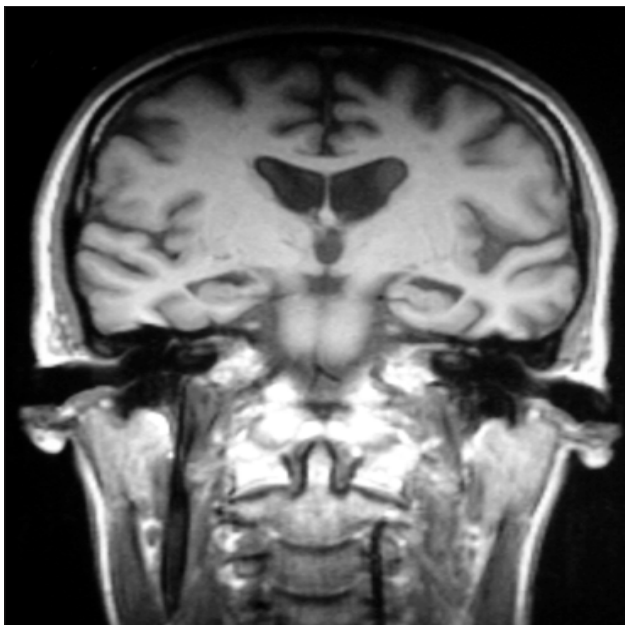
MRI scan showing cortical atrophy and bilateral hippocampal atrophy.
